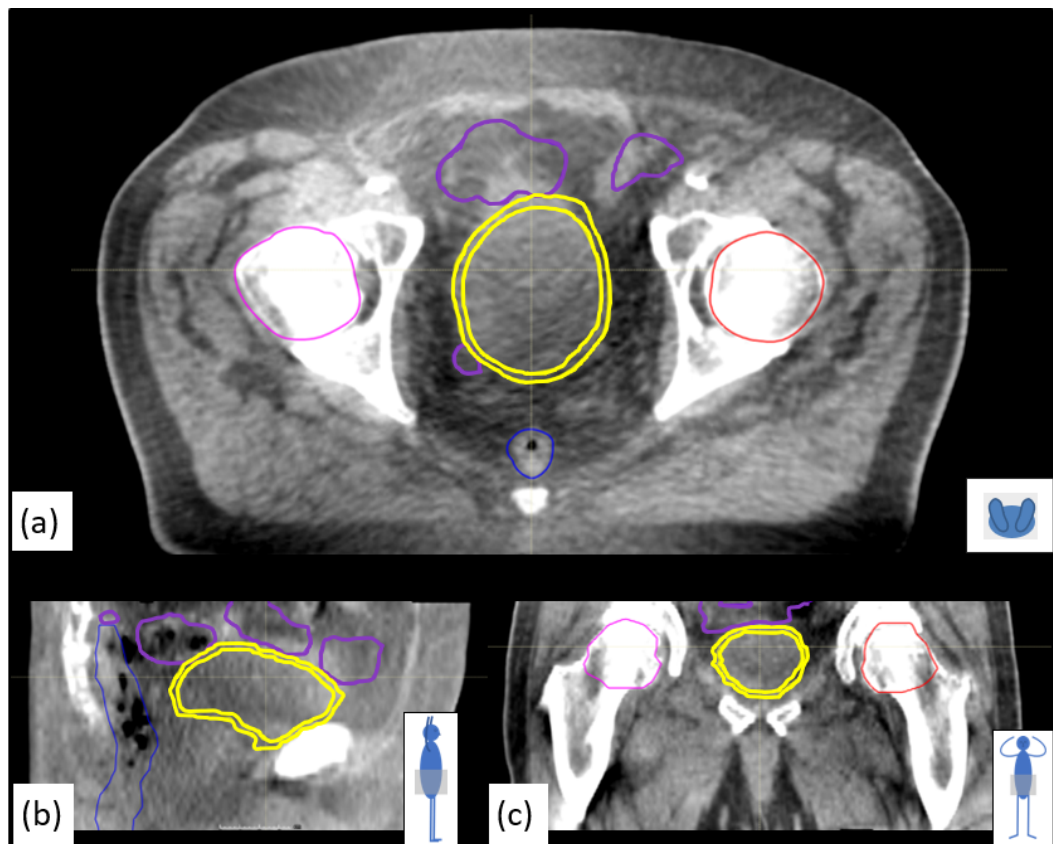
CBCT in (a) transaxial, (b) sagittal and (c) coronal views. The delineated volumes are overlaid from the original planning CT and are as follows: right femur (pink), left femur (red), bowel (purple), rectum (blue) and bladder wall (yellow). Most delineations are in good agreement with the image intensities seen in the CBCT image, apart from the superior and anterior parts of the bladder and neighbouring parts of the bowel.
